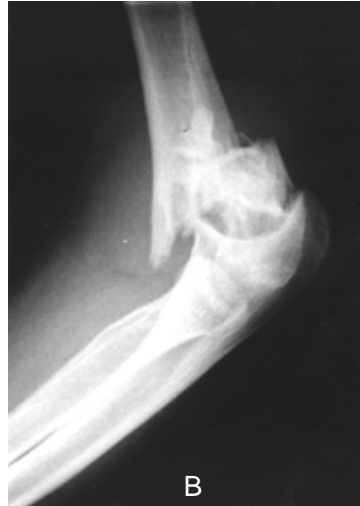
Initial anteroposterior radiograph shows high T fracture which both columns are fractured above the olecranon fossa
